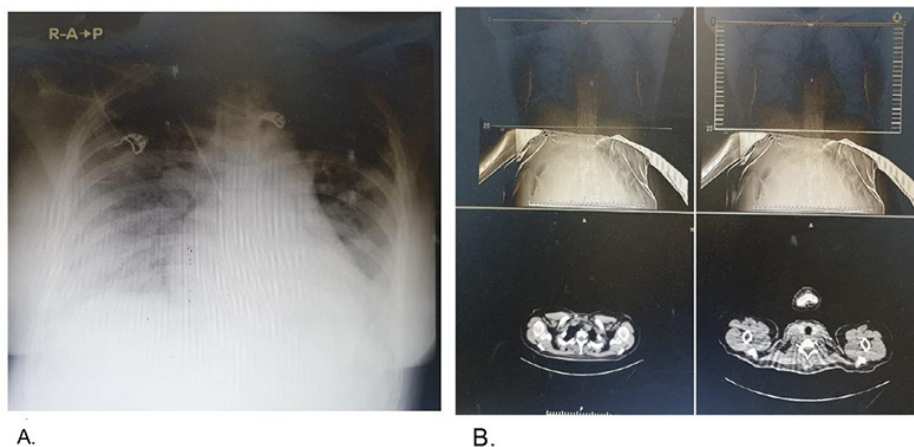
X-ray thorax and Computed tomography (CT) scan of COVID-19 patients in a Pregnant woman. A). X ray thorax dated 28th January 2021, an impression of pneumonia. B). CT scan thorax, dated 28th January 2021, an impression of multifocal ground-glass opacities, subpleural, in the upper to lower fields of both lung fields and accompanied by the consolidation of viral pneumonia typical appearance according to Radiological Society of North America Chest CT classification system.
